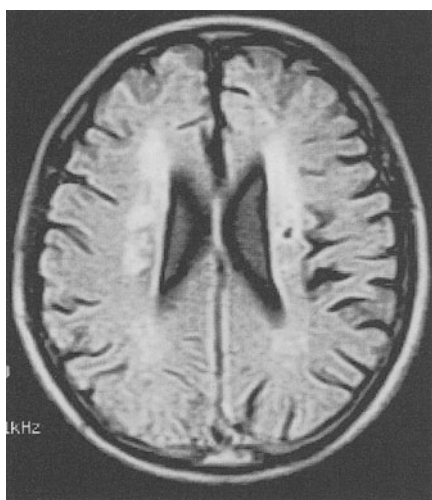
FLAIR image (TR 5500, TE 112, TI 1550) demonstrating periventricular and subcortical white matter disease on a GE 0.2-T open MRI system
